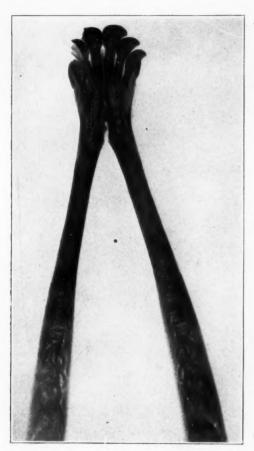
Radiograph of teeth of wild hog.
